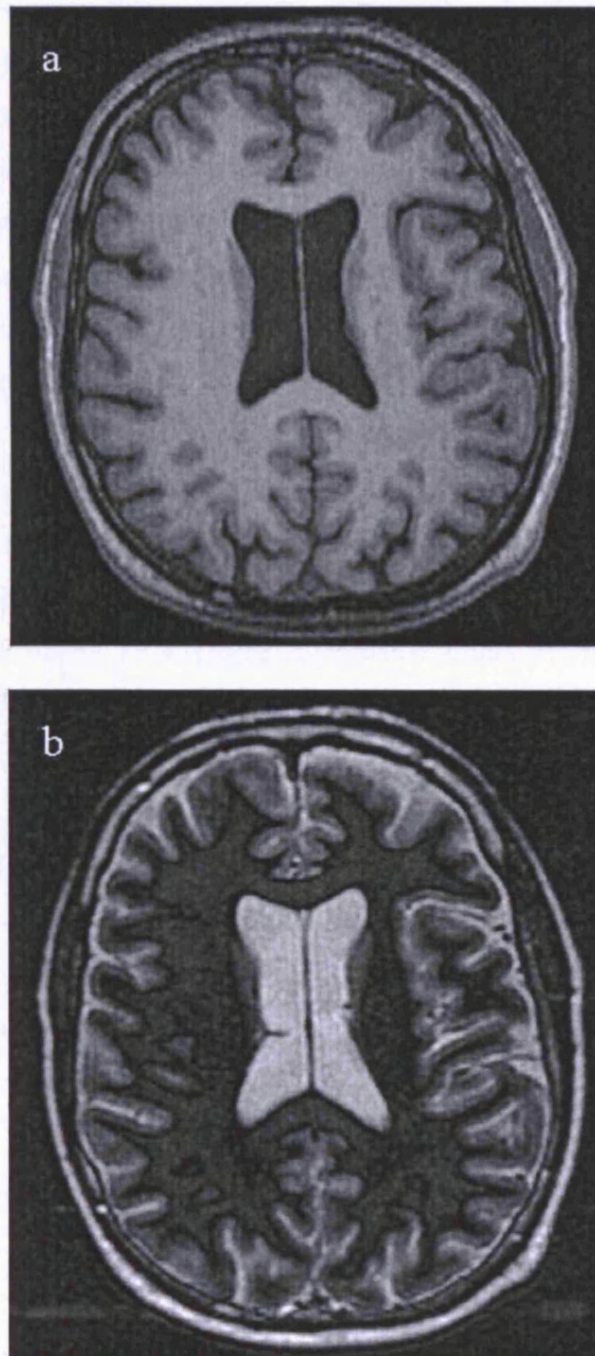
a) A “slice” of a T1-weighted MR image and b) T2-weighted MR image of the brain.
